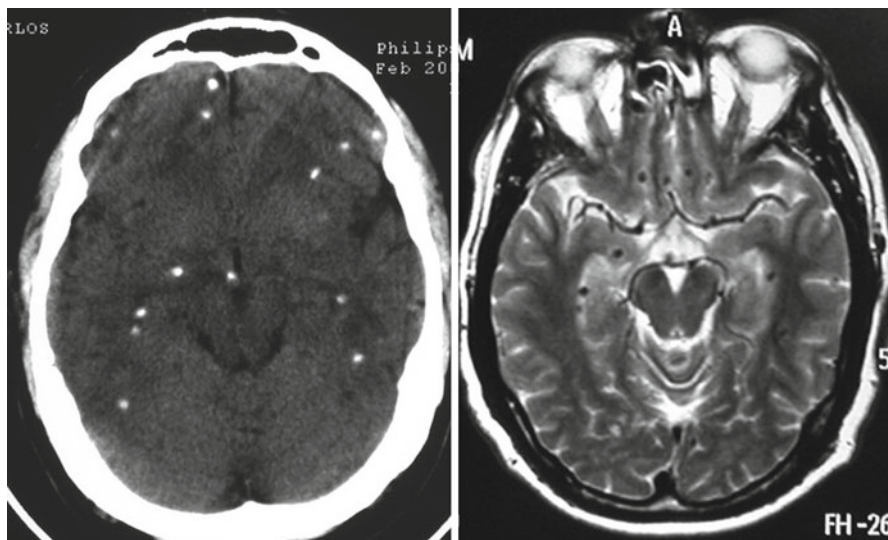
Contrast-enhanced CT (*left*) and T2-weighted MRI (*right*) showing multiple parenchymal brain calcifications, which are more easily discernible with CT than with MRI
